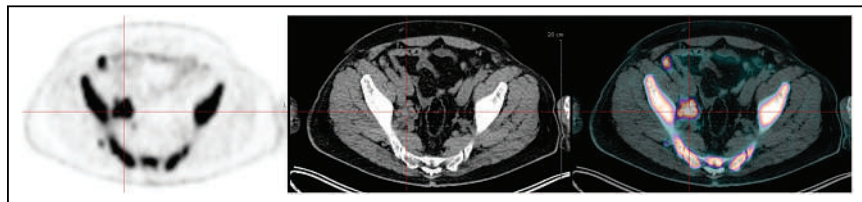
Axial PET (left), CT (middle), and PET/CT (right) images of right iliac lymph nodes with high ^{18}F -FDG avidity. Biopsy favored extramedullary disease.
